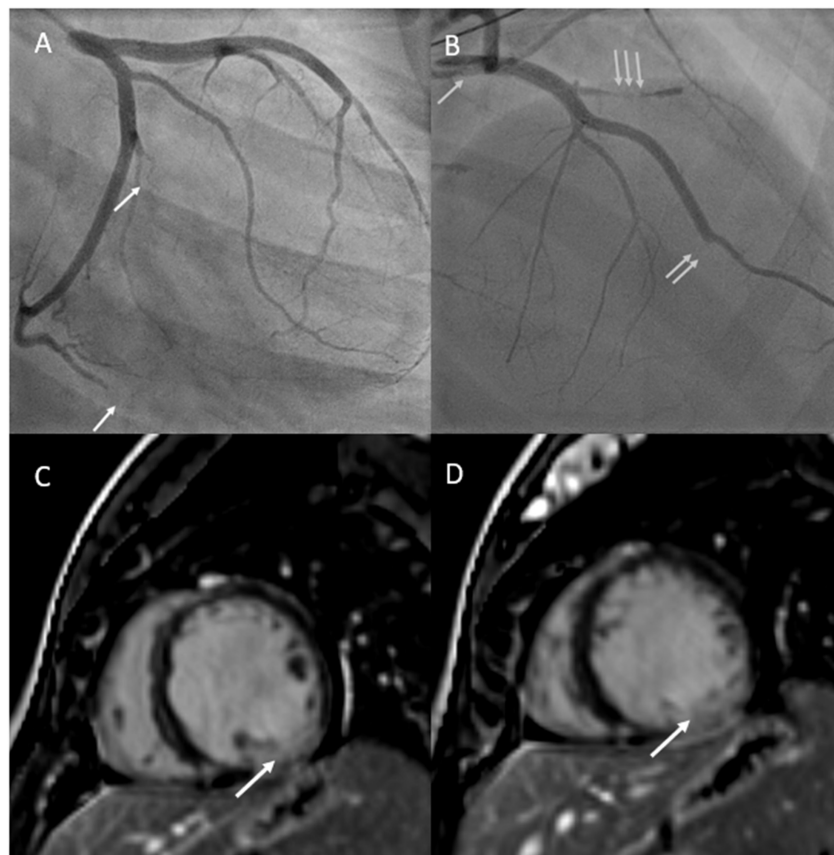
(A) Depicts cardiac angiogram demonstrating occluded cardiac marginal arteries (arrows). (B) Depicts cardiac angiogram demonstrating dissected left main coronary artery (single arrow), occluded left anterior descending artery (double arrow), and occluded diagonal artery from the left anterior descending artery (triple arrow). (C,D) Reveal cardiac MRI with gadolinium enhancement with phase sensitive inversion recovery showing basal to mid transmural late gadolinium enhancement in the inferior and inferolateral walls (left circumflex artery territory) secondary to spontaneous coronary artery dissection.
